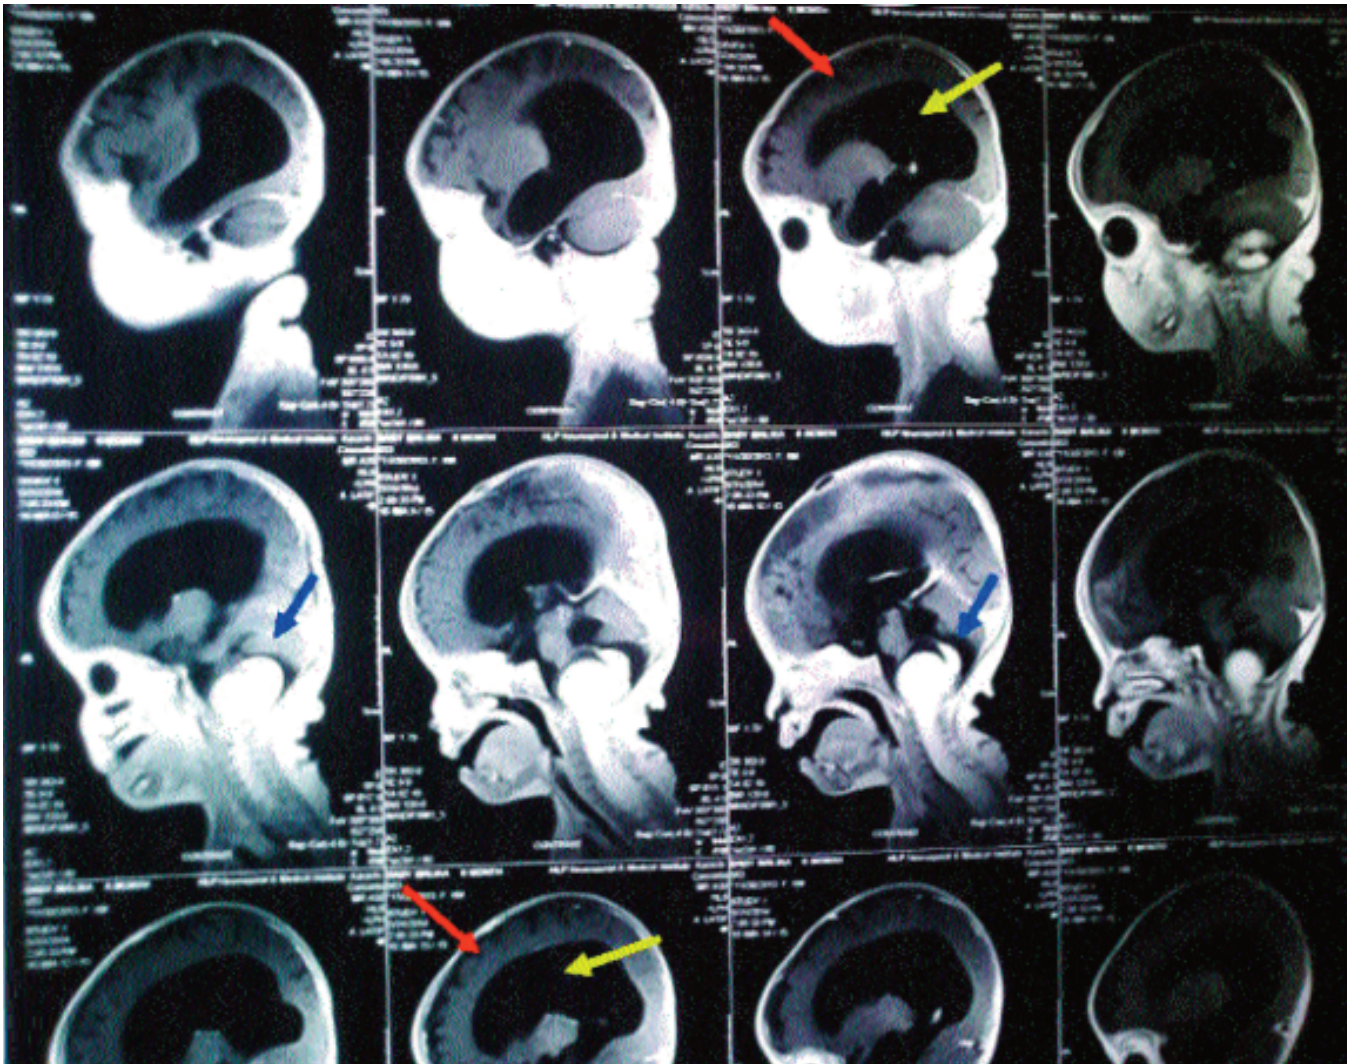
An MRI brain with contrast showing marked cortical atrophy (red arrow), gross dilation of lateral and 3rd ventricles (yellow arrow), space occupying lesion (lipoma) in the posterior cranial fossa (blue arrow) extending into the cervical canal causing obstructive hydrocephalus.
